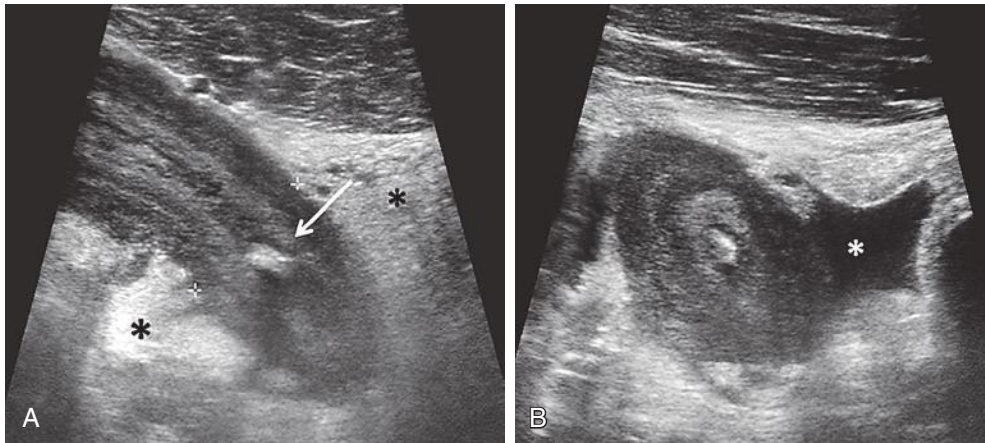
Acute appendicitis. A, Targeted ultrasound examination of the right lower quadrant performed with a linear high-resolution transducer shows distended thick-walled appendix (*calipers*) with echogenic, shadowing intraluminal appendicolith (*arrow*). The surrounding periappendiceal fat demonstrates increased echogenicity (*asterisks*) compatible with inflammation. B, Transverse image demonstrates periappendiceal fluid (*asterisk*).
